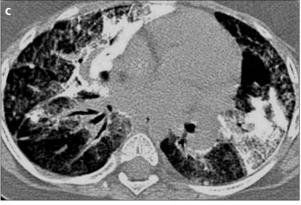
a-c. Axial CT images (a-c) show bilateral areas of consolidation in a patchy distribution and ossified areas. Right hilar lymphadenomegalies are present (a). The consolidation and ossification have a predominantly peribronchial distribution. Pleural thickening, areas of groundglass attenuation, and irregular linear areas of increased attenuation are also noted (a-c).
